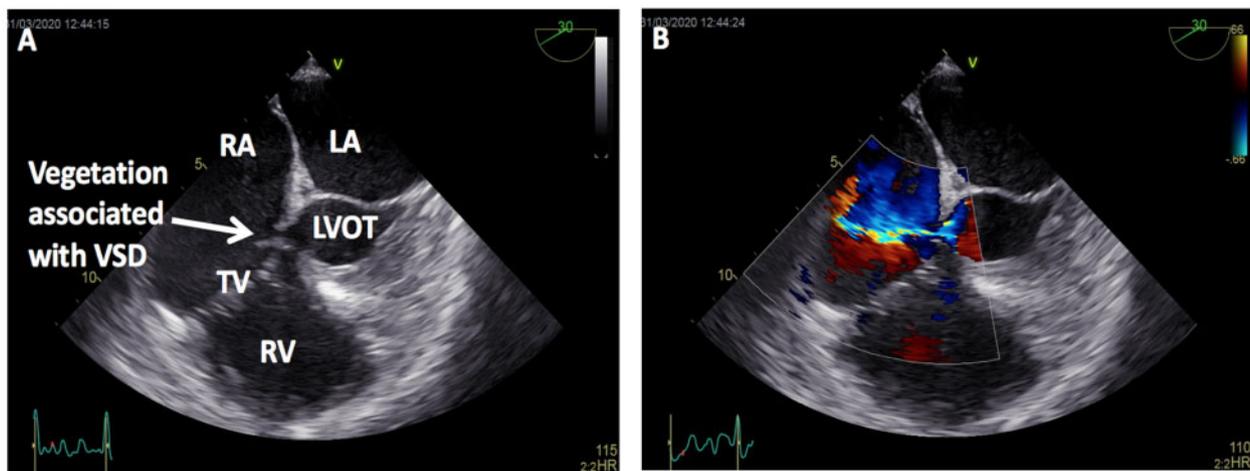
Transoesophageal echocardiogram images. (A) Ventricular septal defect from left ventricular outflow tract to right atrium with an associated vegetation. (B) Colour flow imaging showing high velocity jet from left ventricular outflow tract into right atrium consistent with a Gerbode ventricular septal defect. LA, left atrium; LVOT, left ventricular outflow tract; RA, right atrium; RV, right ventricle; TV, tricuspid valve; VSD, ventricular septal defect.
